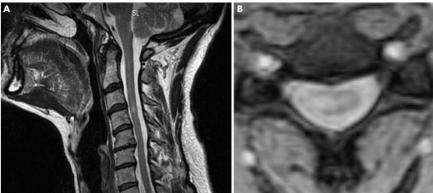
MRI of the cervical spinal cord of a 49-year-old female with CIS showing a lesion at cervical vertebrae C3/4.
